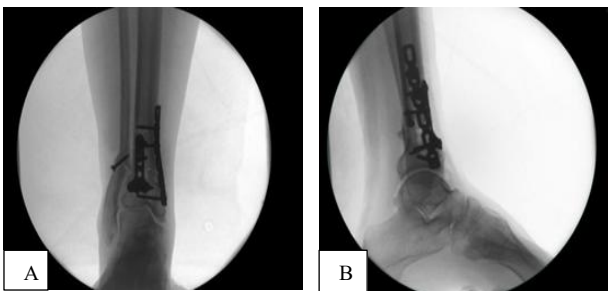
(A and B): medial locking plate and fibular lag screw were applied; final fixation confirmed with radiographs.
